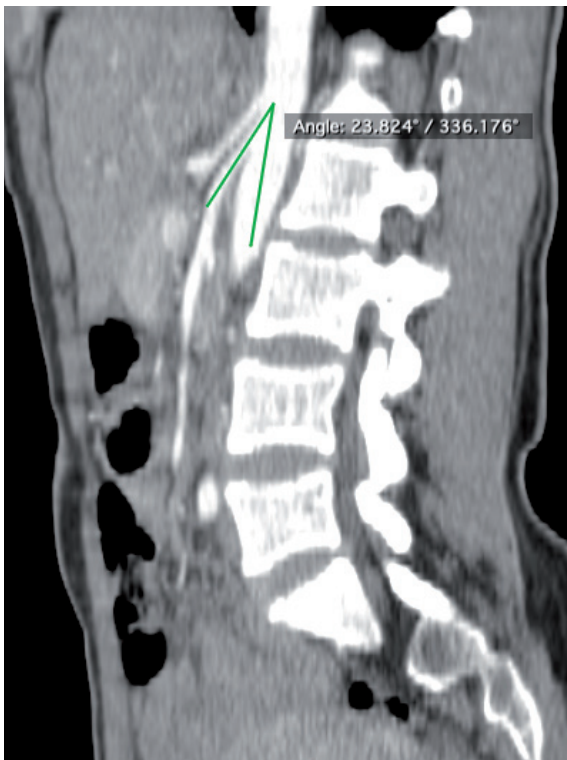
CT signs of NCS in a patient admitted to our department. The angle between SMA and the aorta < 39 degrees
